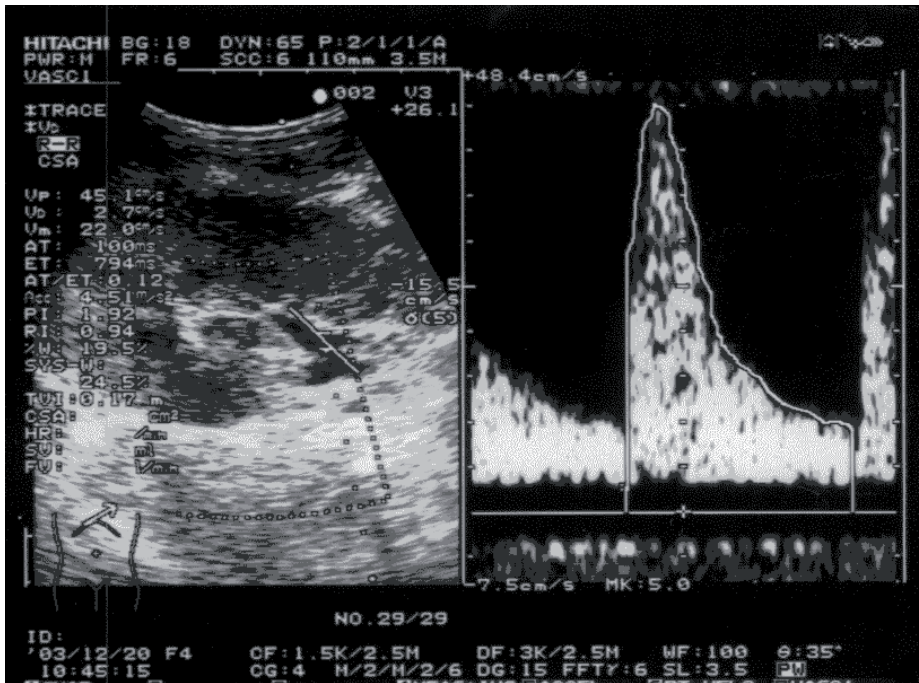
View of intraoperative Doppler ultrasound examination — RI and PI value measurements.
